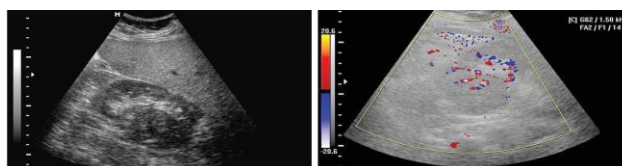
Ultrasonograms of kidney: a — “grey scale” mode — renal cancer (non-uniform volumetric formation without clear contours), b — CDC mode - renal cancer (signs of neoangiogenesis as multiple color signals in the area of volumetric formation).
